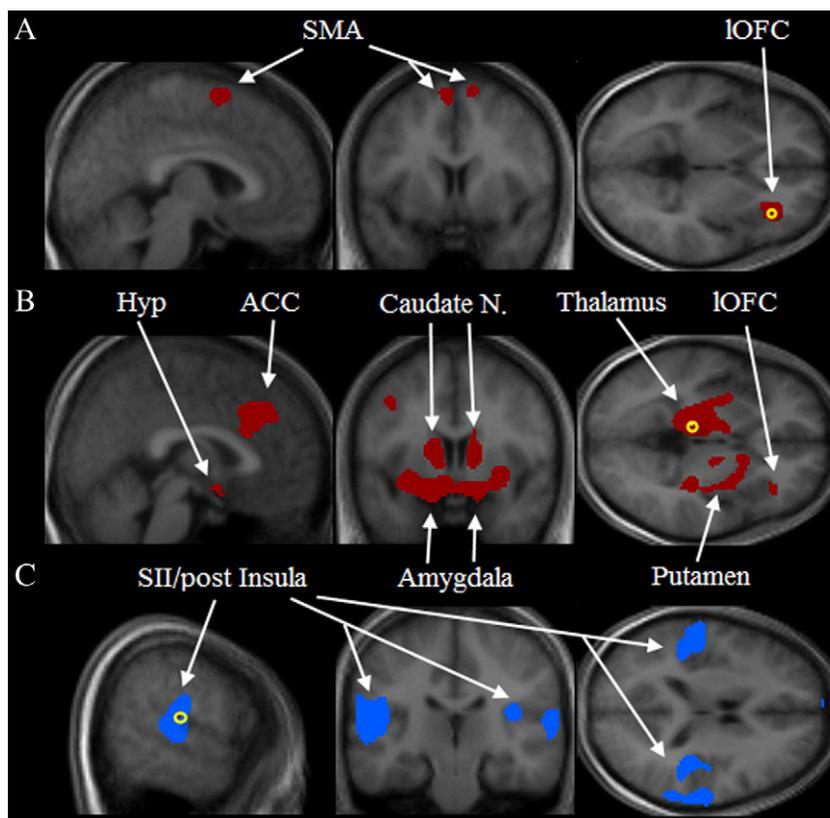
Regions positively covarying with seed regions (yellow circle) for primary dysmenorrhea patients. (A) The right lateral orbitofrontal cortex (IOFC) positively covaried with bilateral supplementary motor area (SMA). (B) The left ventral posterior thalamus positively covaried with the hypothalamus (Hyp), anterior cingulate cortex (ACC), caudate nucleus, amygdala, ventral putamen and right IOFC. (C) The left secondary somatosensory area (SII) positively covaried with right SII and bilateral posterior insula. Results are superimposed on the averaged anatomical T1 MRI from patients. Red and blue colors represent regions with increased or decreased activity relative to onset in patients from Fig. 1.
